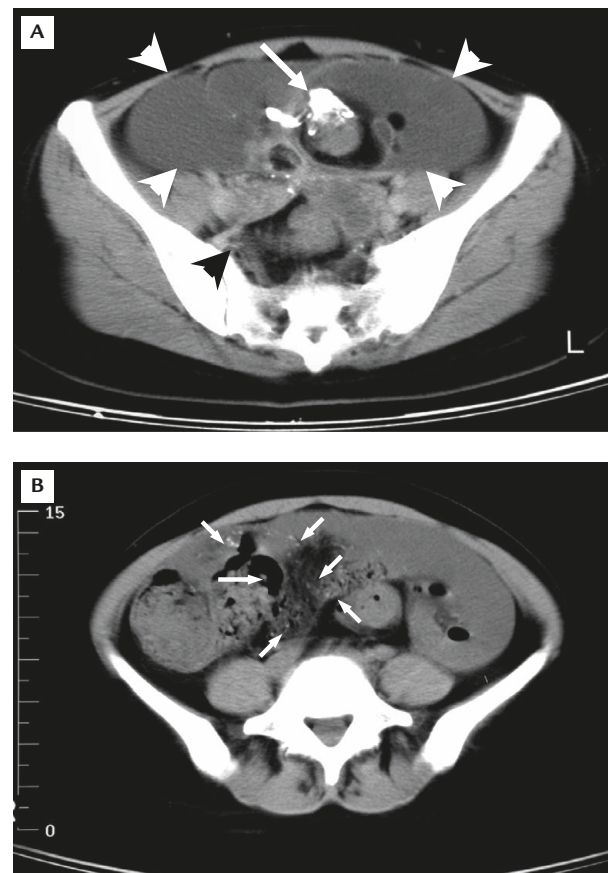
Abdominal computed tomography scan shows: (A) a large heterogeneous multiloculated mass (arrowheads) with areas of soft tissue, adipose density and calcification (arrow) within it; and (B) disseminated calcified spots (arrows) on the mesentery.
